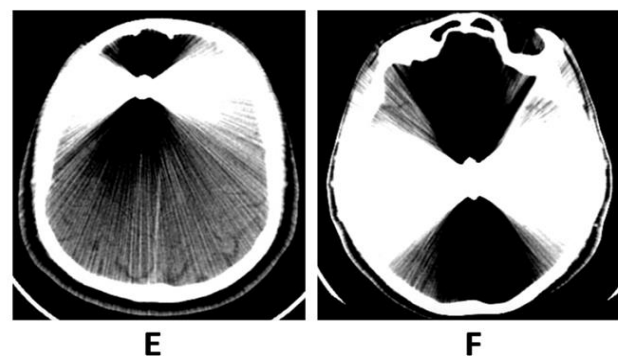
Head CT in cross-sectional view, E: before bullet migration, F: after bullet migration.
